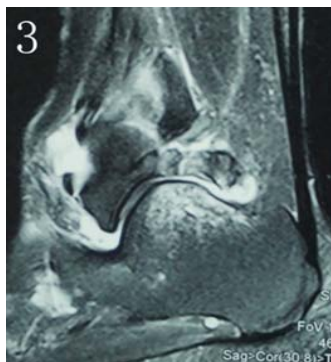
MRI showing high signal in the os trigonum and the normal signal in the talus.
